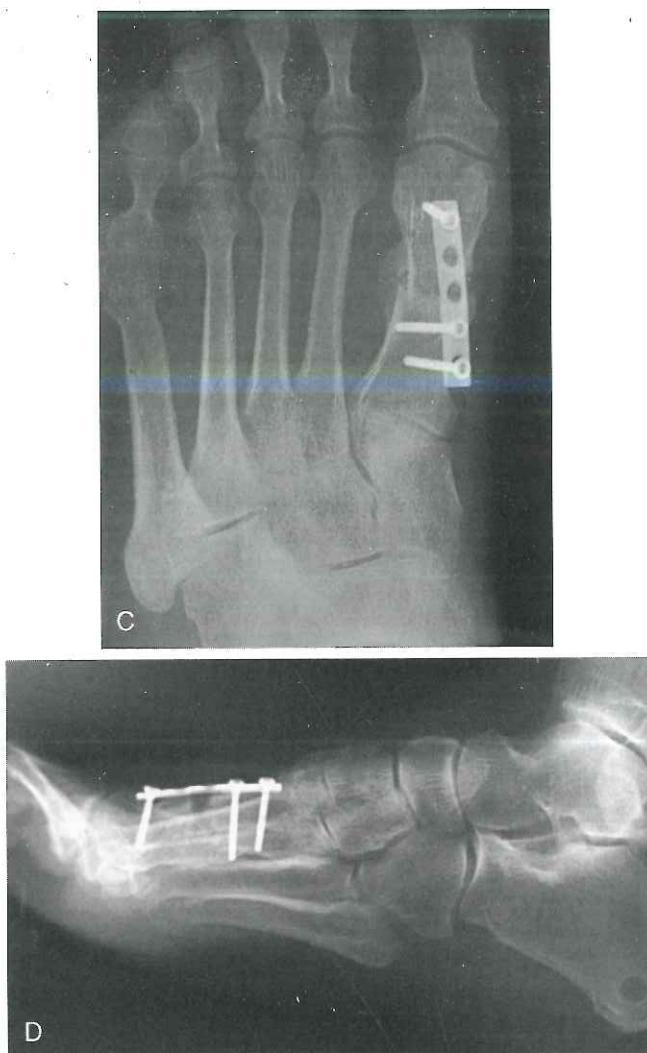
Anteroposterior (A) and lateral (B) radiographs of a patient with a first metatarsal stress fracture that healed with a dorsal malunion.
